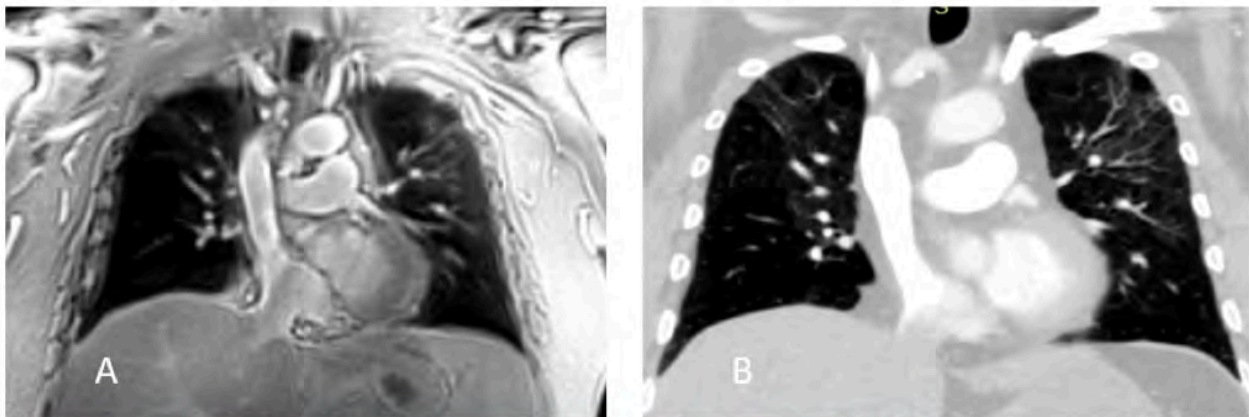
Example of Spiral UTE MRI (A) with good diagnostic quality compared to CT (B).
